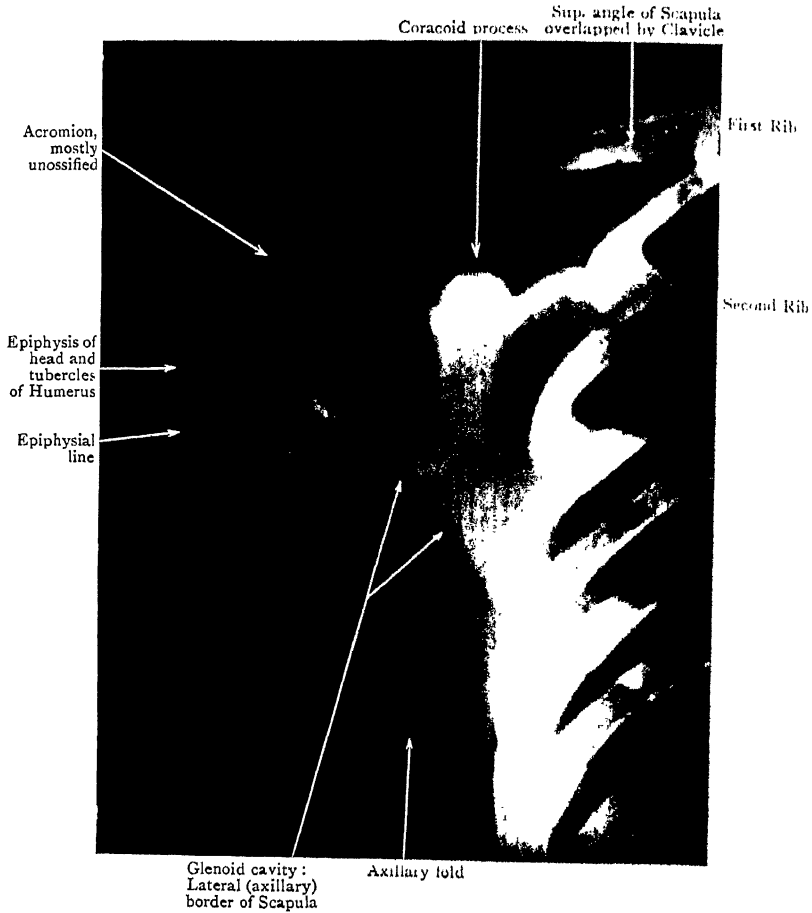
Radiograph of Shoulder Region of boy aged 7.
